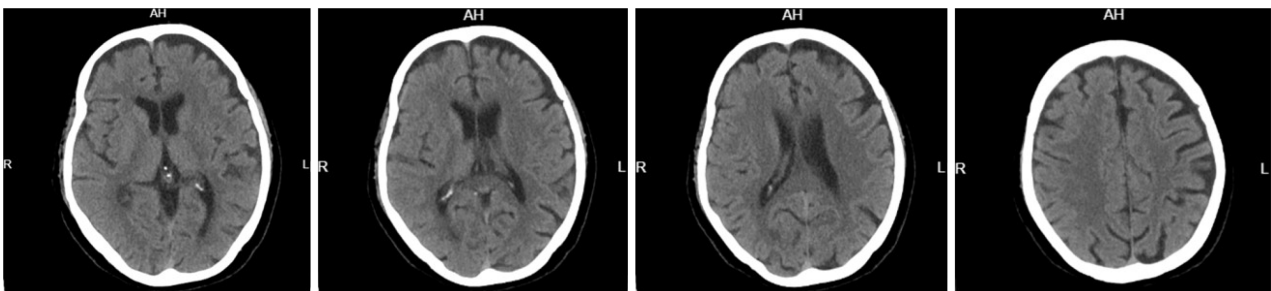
Head computed tomography. The cerebral hemispheres are symmetrical. The brain volume is reduced, and the sulci are deepened and widened. The ventricular system and sulcal fissure are widened. The midline structures are centered.
